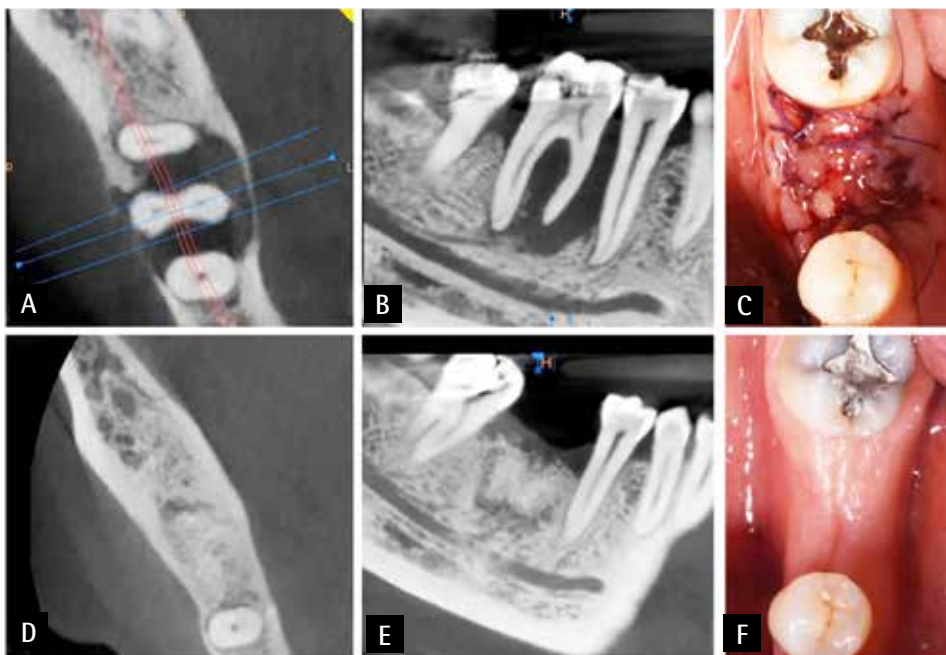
Before and after alveolar ridge preservation, cone beam and clinical images: bone morphology prior to extraction and alveolar ridge preservation (A, B); intraoral view at the time of surgery (C); one year post-operative (D, E); intraoral view of the edentulous site after healing (F).
